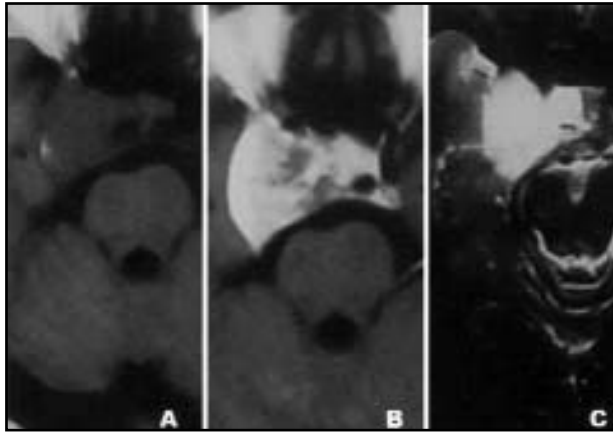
Patient 1. Well-circumscribed right para-sellar and supra-sellar mass, slightly hypointense in T1-weighted sequence (1A), showing intense enhancement after gadolinium infusion (1B) and high signal intensity in T2-weighted image (1C). A small hemorrhagic focus is seen peripherally located, due to previous biopsy. Lesion encircles right internal carotid artery.
